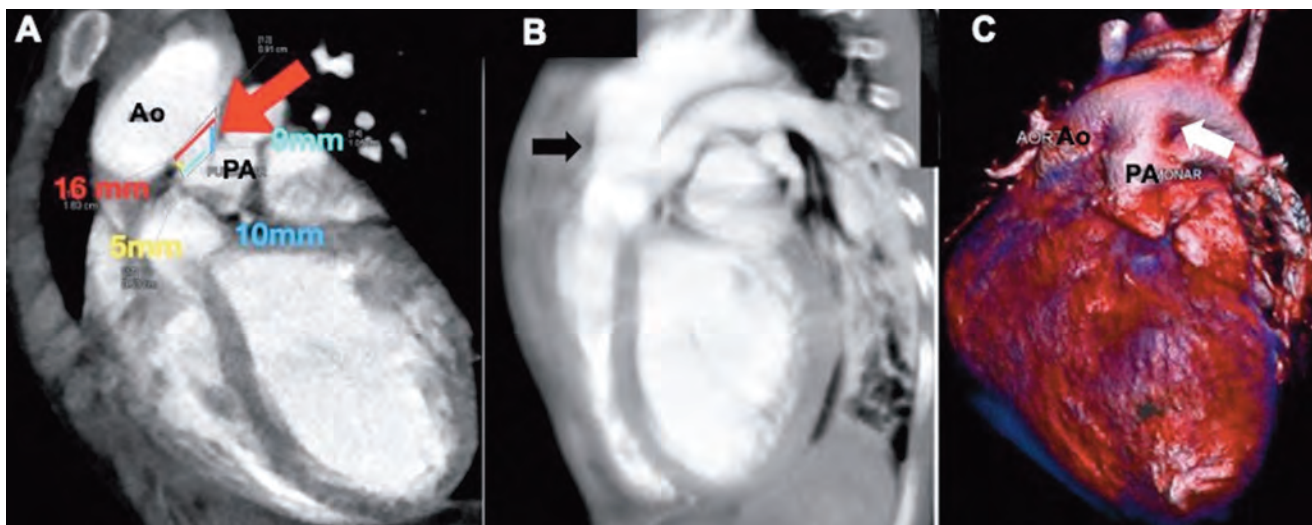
Computed tomography with sagittal reconstruction, shows: A) APW measurements (red arrow) and B) the relationship with the valves and bifurcation of pulmonary branches (black arrow). C) 3D reconstruction shows type I morphology (white arrow). Ao: Aorta, PA: Pulmonary artery.
